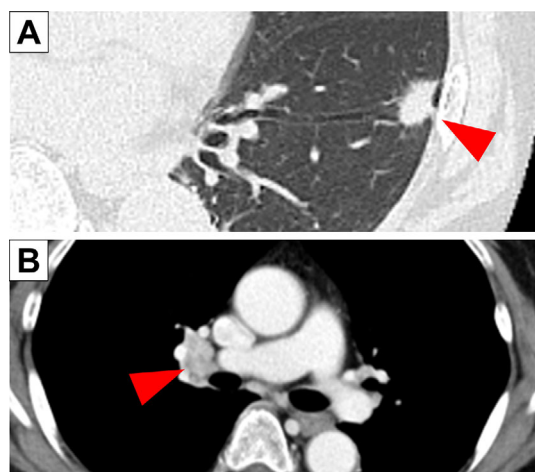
Chest computed tomography, showing (A) a 14-mm lung tumor in the left lower lobe (arrowhead) and (B) hilar lymphadenopathy (arrowhead).
